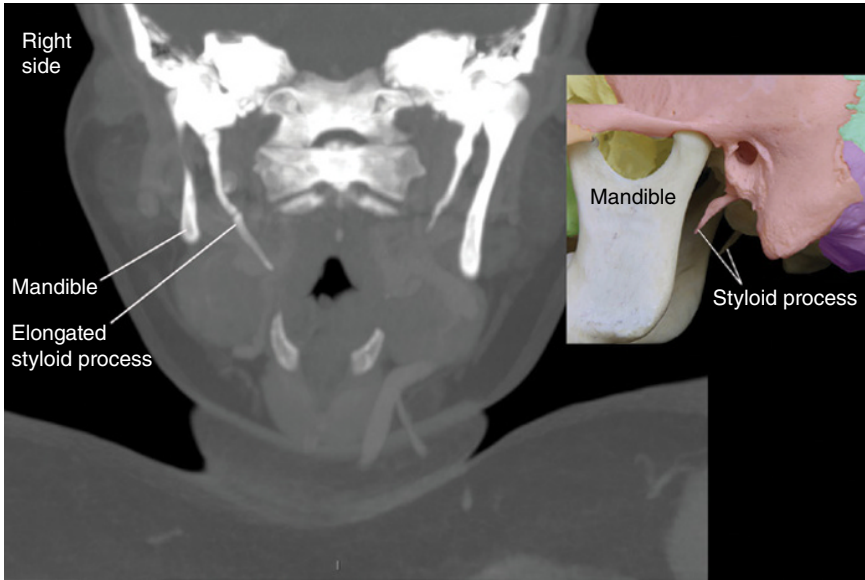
The main image shows a coronal view CT scan (it is as if you are looking at the patient’s face) of a disproportionately long, right styloid process; note specifically that it extends beyond the lower border of the mandible, which is not normally the case as shown by the inset, which depicts a lateral view of the middle of a normal skull in which leaders point to both normal styloid processes (see Figure 1.25). The CT also shows that the patient’s left styloid process is similarly enlarged, although to a lesser extent than on the right.
